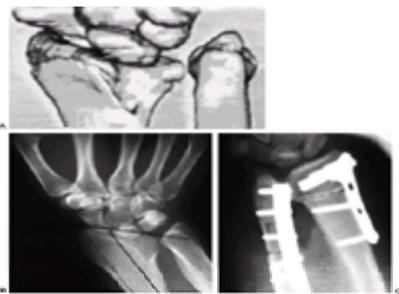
A: MRI scan of severe Madelung deformity. Note that the lunate fossa is markedly deficient and oriented ulnarly. B: Preoperative radiograph of a patient with Madelung deformity and debilitating ulnocarpal and radioulnar pain. There is nearly complete deficiency of the lunate fossa and subluxation of the carpus ulnarly, volarly, and proximally. The ulnar has a positive variance. C: Postoperative radiograph of a radiodorsal closing-wedge osteotomy of the radius and ulnar Z-shortening osteotomy in this patient. This procedure restored radial articular alignment, corrected the ulnocarpal impaction, and reduced the distal radioulnar joint.
